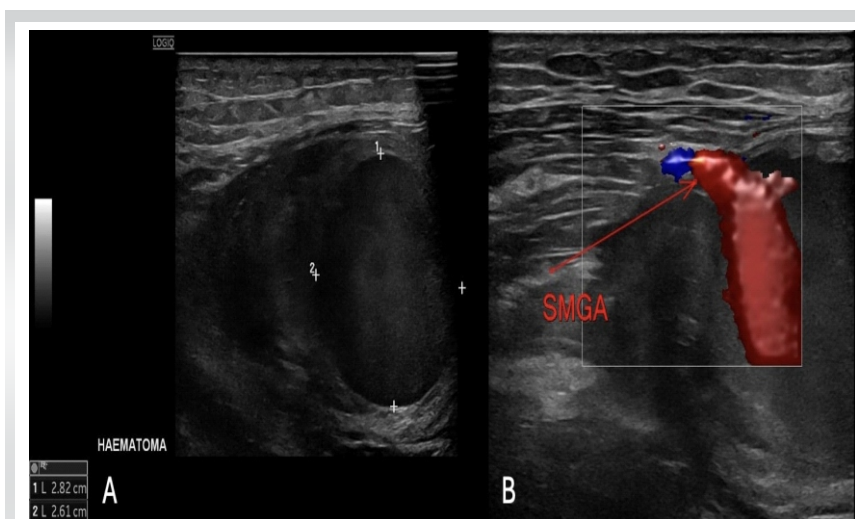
(a) Repeat Duplex Doppler ultrasound showing a large haematoma anterior to the left femur with active bleeding. (b) The source of the active bleeding was the superior medial genicular artery.
